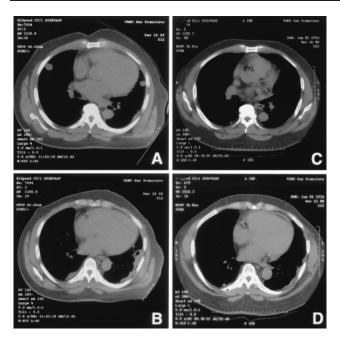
A, B, Chest computed tomographs of Patient 3 obtained in December 1999. Multiple nodules are present at the pleural surfaces bilaterally. A cavitating lesion can be observed in the left lung. C, D, Chest computed tomographs of Patient 3 obtained November 2000. Images from levels corresponding to the prior scan demonstrate remarkable resolution of these lesions.
